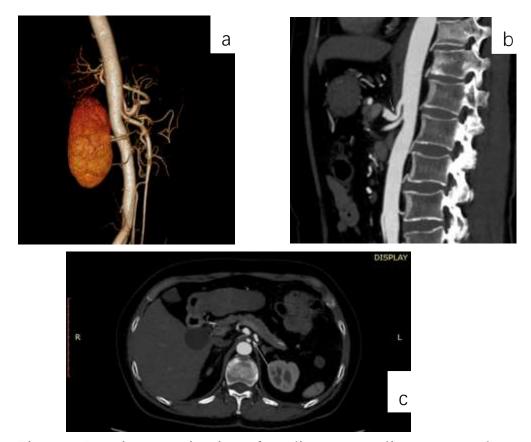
Imaging examination of median arcuate ligament syndrome. A, B: computed tomography (CT) angiography coronal images showed a V-shaped stenosis at the beginning of the celiac trunk (the arrow indicates) and distal expansion; C: CT showed compression at the beginning of the celiac trunk (indicated by arrow).
